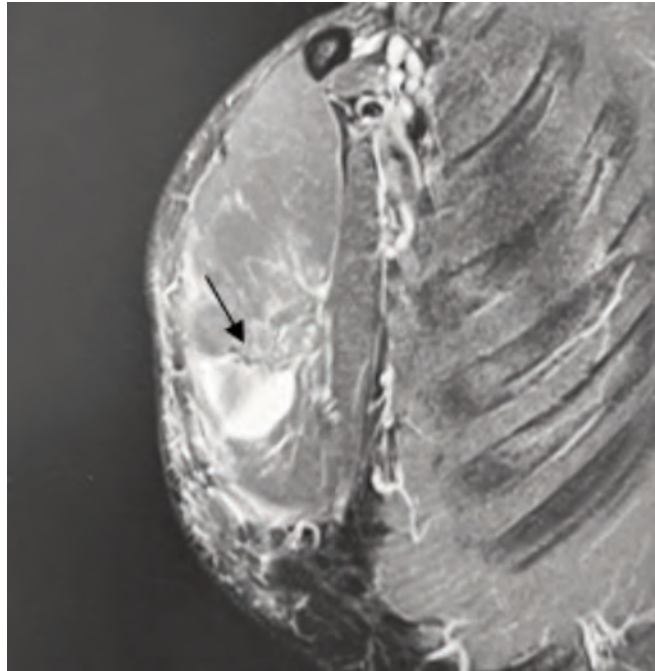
Coronal magnetic resonance imaging showing a complete rupture of the pectoralis major muscle tendon (indicated by black arrow).
